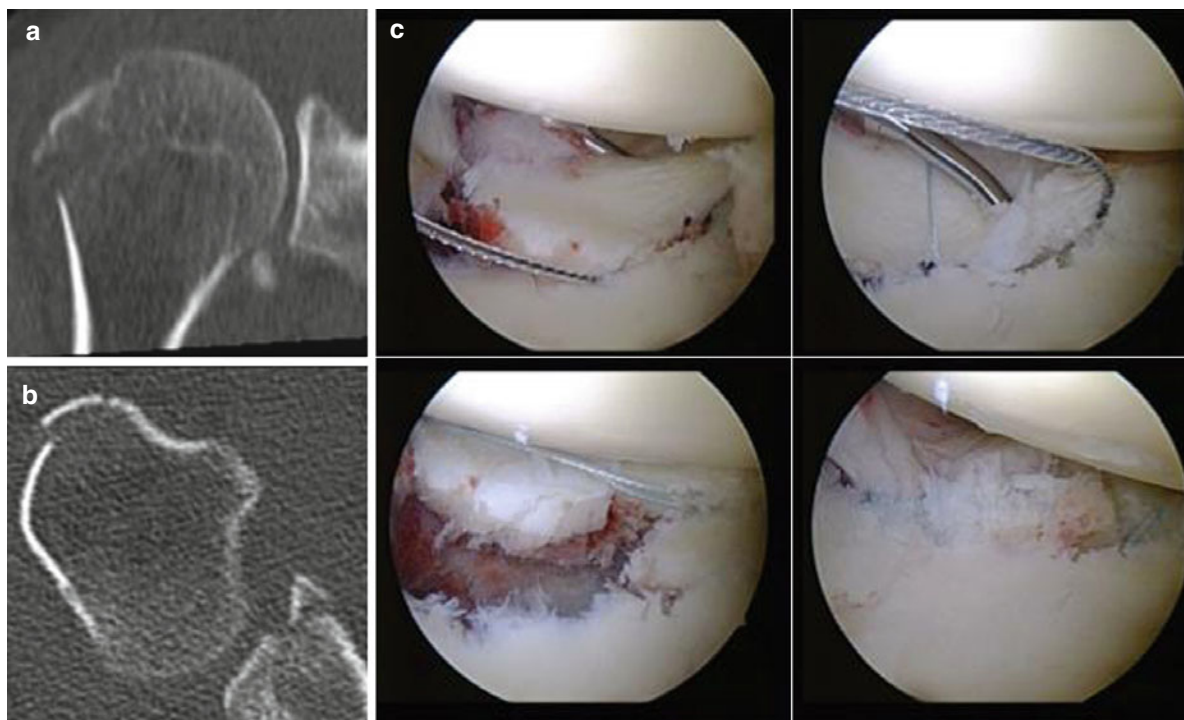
Arthroscopic repair of a bony Bankart lesion. (a, b) Preoperative CT scan demonstrating an anterior bony Bankart lesion. (c) Stepwise arthroscopic fixation of the bony Bankart lesion using suture anchors
